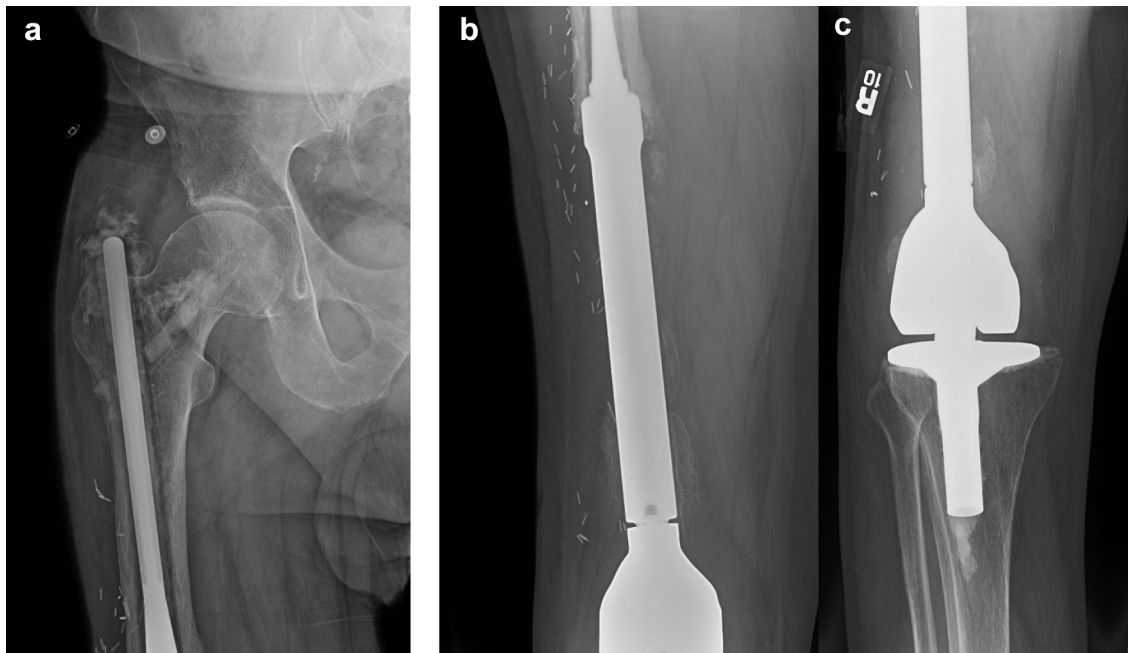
AP radiographs of a hip (a), femur (b), and knee (c) demonstrating a loose distal femoral replacement arthroplasty with loss of a large segment of distal femur and considerable damage to the proximal femur.
